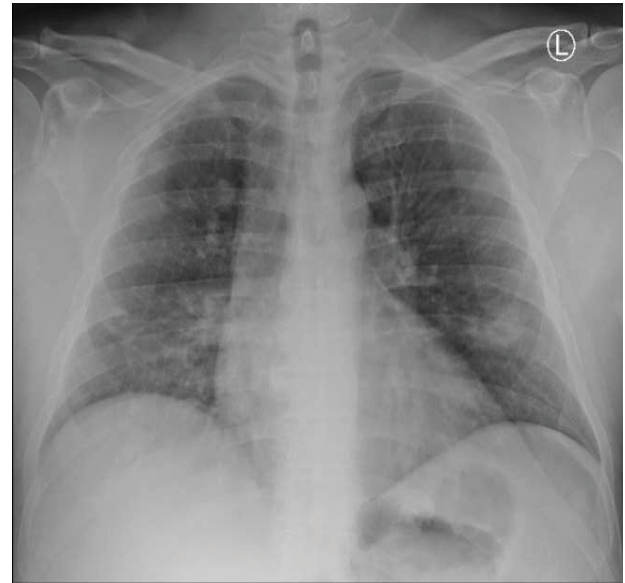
Chest X-ray performed on admission. Initial Radiologic evaluation demonstrated a new cavitary lesion involving left mid lung zone, which was interpreted as a lung abscess.a
